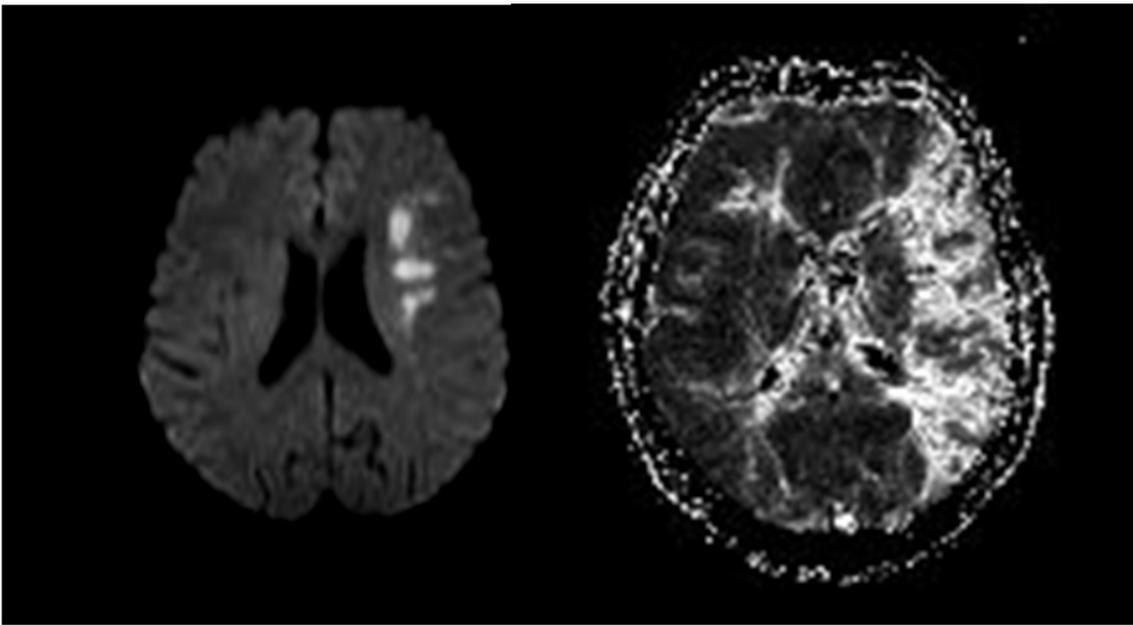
Hyperacute ischemia (left) might be normal on DWI.
